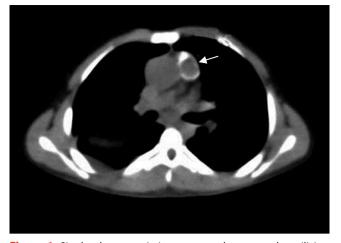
Single-photon emission computed tomography utilizing 99mTc-HMPAO (exametazime) labeled leukocytes. Increased accumulation of marker in the region of pulmonary trunk with visible multiple calcifications – the image seems to correspond to the presence of inflammatory process in this area (arrow)
